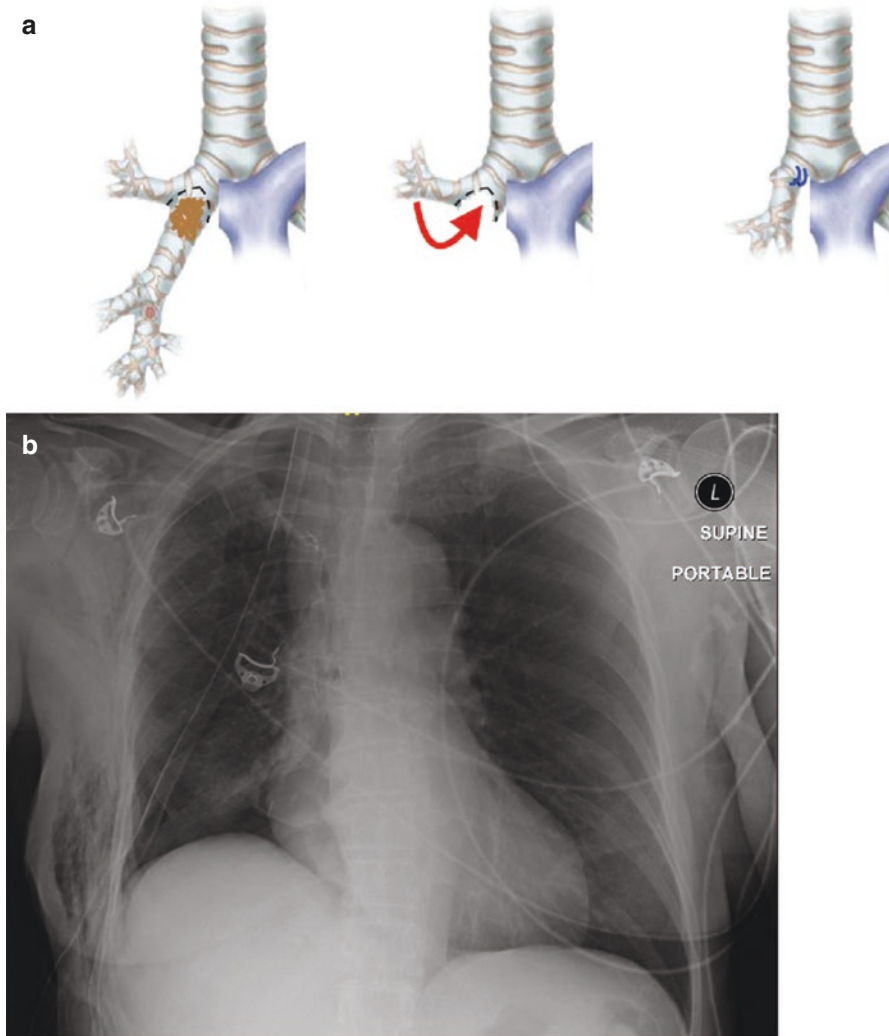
Hinge bronchoplasty of the right upper lobe may be indicated during bilobectomy if the tumour involves the medial wall of the main bronchus opposite the right upper lobe ostium. The right upper lobe is swung inferiorly and medially to anastomose onto the end of the main bronchus to create a valuable functioning neo-lung (a). A post-operative chest X-ray demonstrates the repositioned lobe almost filling the pleural cavity (b)
